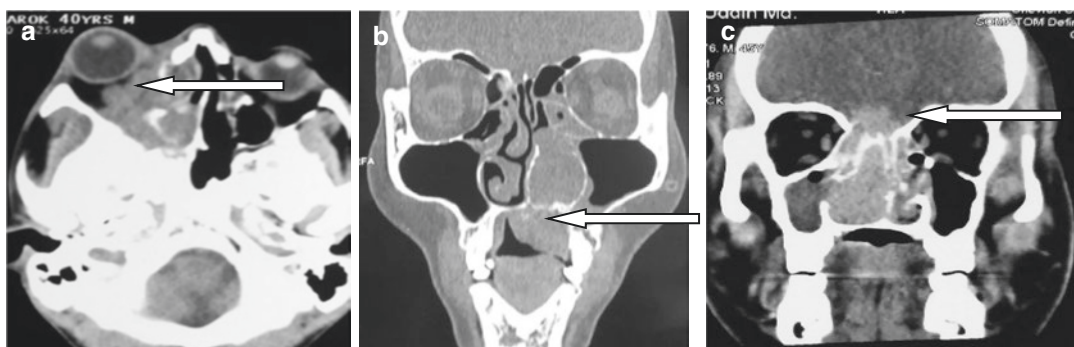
(a–c) CT scans of sino-nasal carcinoma: (a) ocular extension, (b) palatal extension, and (c) intracranial extension
